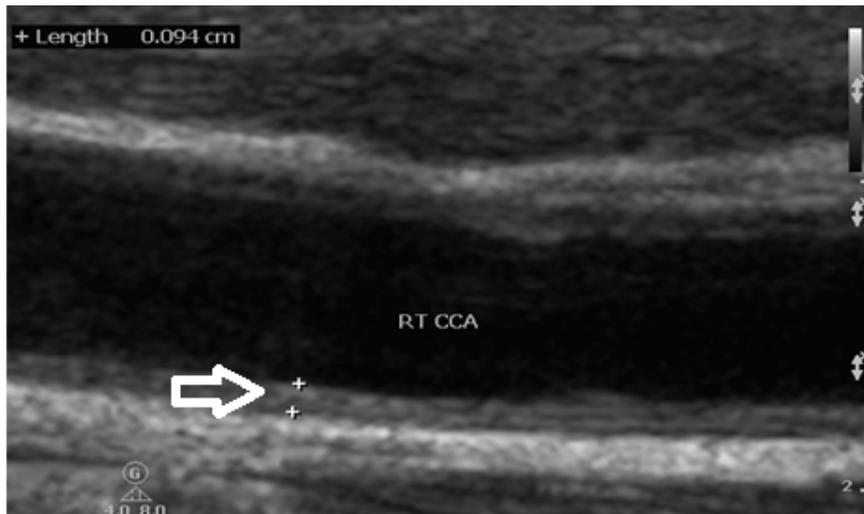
B-mode (gray scale) ultrasound image shows thickened intima media of Rt common carotid artery (RT CCA) = (0.094) in RA patient.
